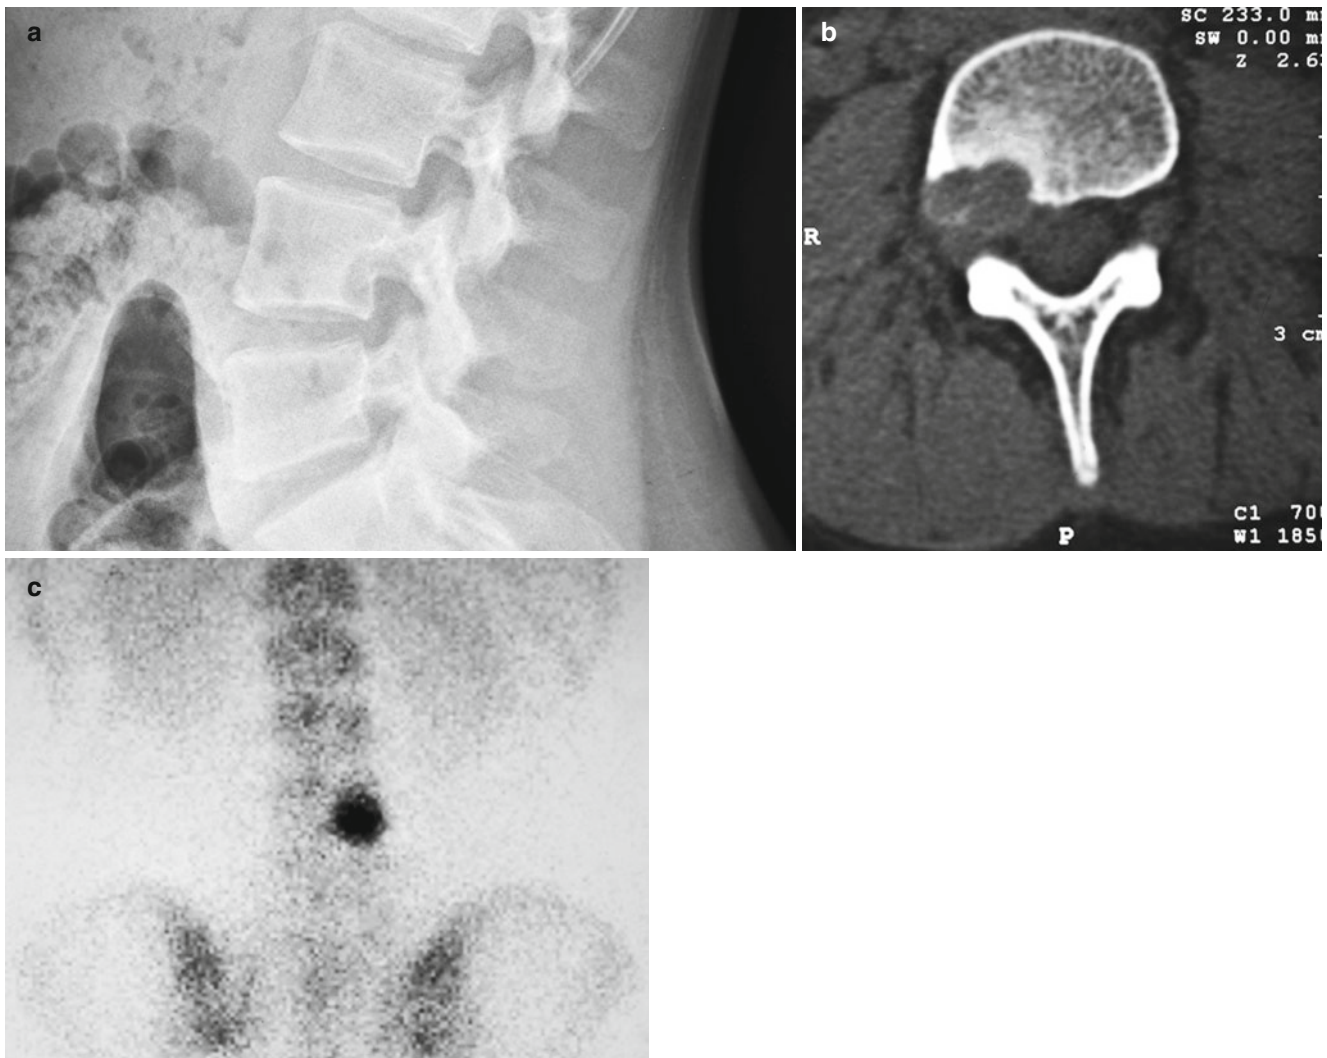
Rarely, osteoblastoma involves the vertebral body alone, as can barely be seen by conventional radiography (a) and more easily identified by CT (b) and bone scan (c)
